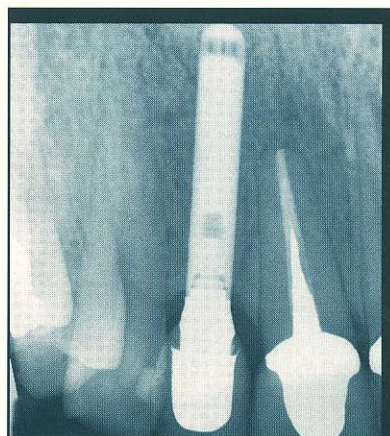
The 2-year postoperative radiograph of the implant demonstrates the integration of the implant fixture within the patient's maxilla.
